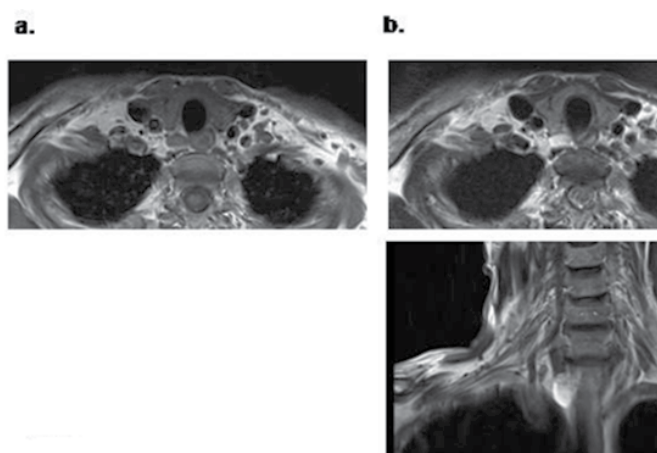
Magnetic resonance imaging showing a mass in the right neck which showed low to intermediate signal intensity on T1-weighted images (a) and high signal intensity on T2 images (b) compared to the surrounding tissues.
